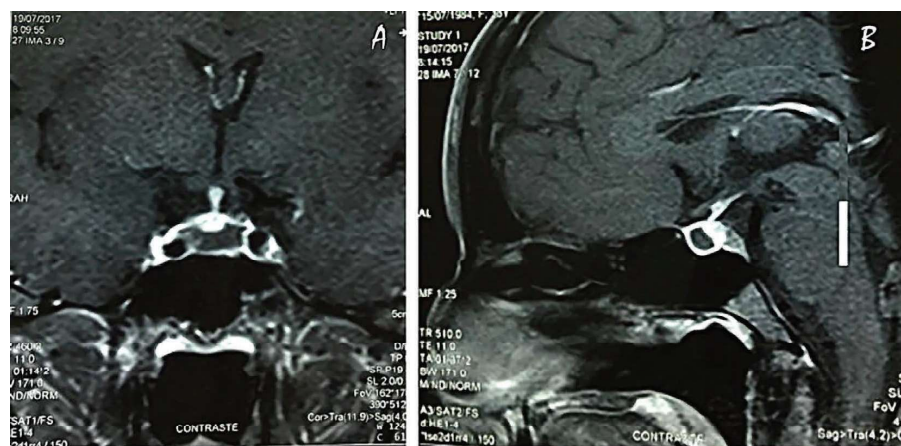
Coronal (a) and sagittal (b) postcontrast MRI at diagnosis. It shows an enlarged pituitary gland with suprasellar extension, peripheral enhancement of the pituitary gland, and irregular and poorly enhanced central portion after gadolinium injection.
